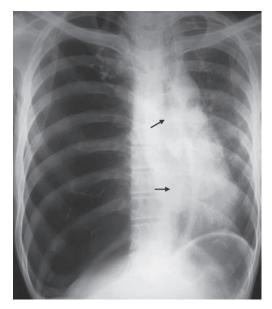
Chest X-ray shows a hyperlucent lung on right side with inversion of right dome of diaphragm and mediastinal shift to opposite side (arrows) herniating into the left hemithorax
